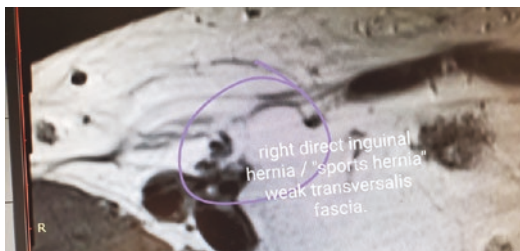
Sports hernia on MRI
